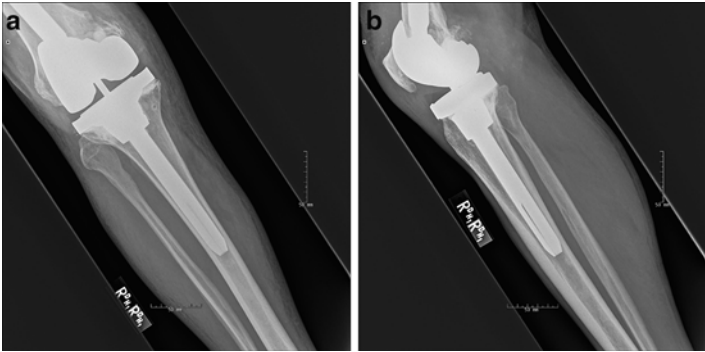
Postoperative week 8 AP (a) and lateral (b) radiographs demonstrate stemmed femoral and tibial components in good overall alignment.
